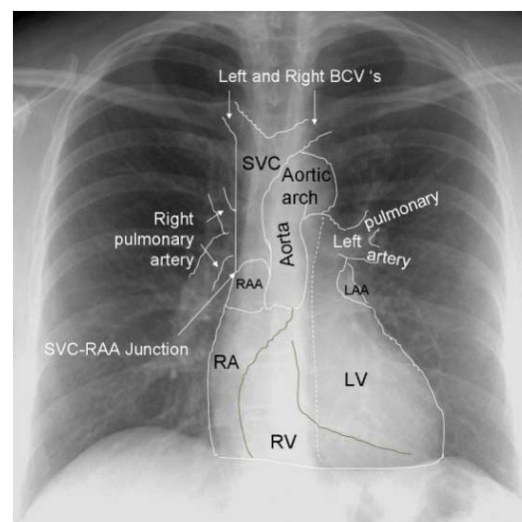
Right and left mediastinal borders, as seen on the frontal chest radiograph
